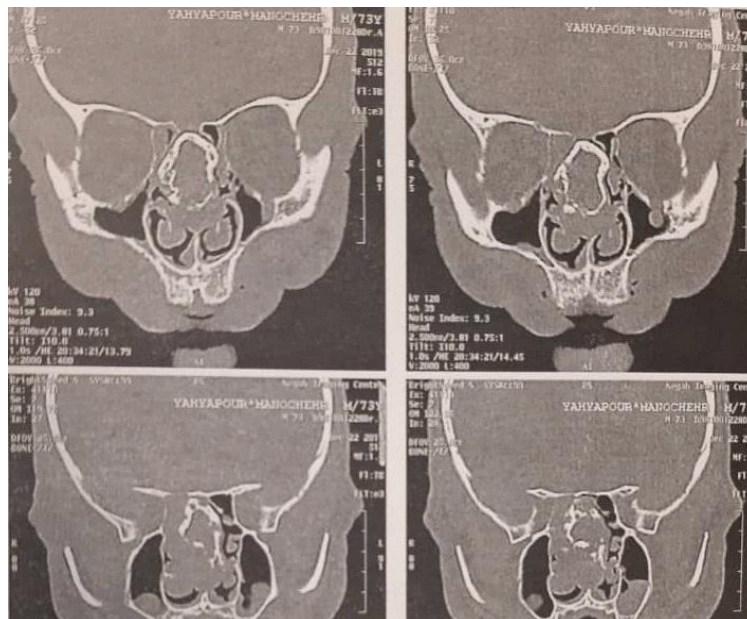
Chondrosarcoma CT-scan of nasal cavity with coronal cut.
